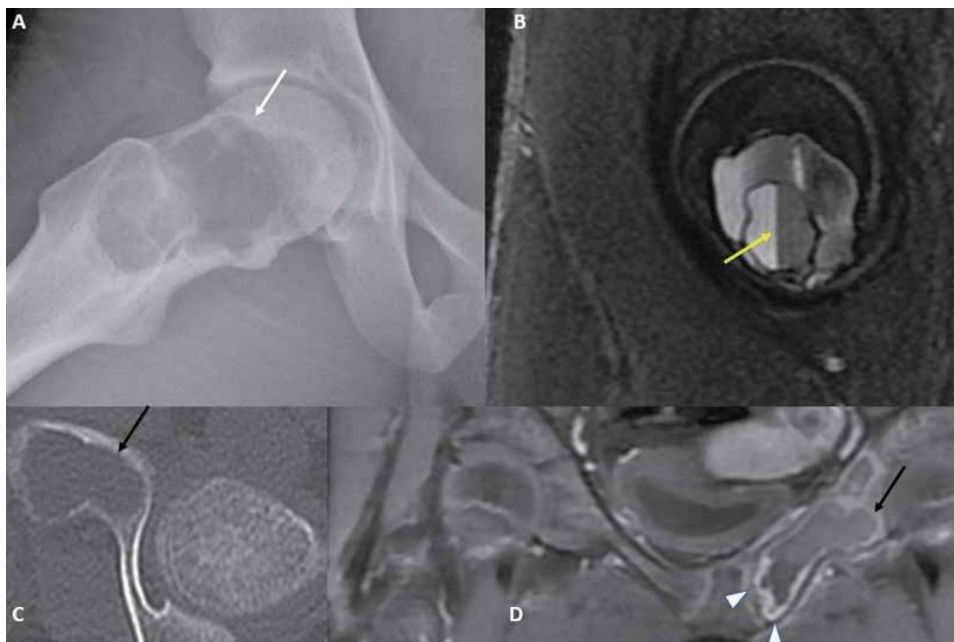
Aneurysmal Bone Cyst: Lateral radiograph of the pelvis (A) shows an expansile, circumscribed, lytic, proximal femoral metaphyseal lesion (white arrow) with scalloped margins. On axial fat-saturated T2-weighted imaging (B), the lesion shows multiple fluid-fluid levels within (yellow arrow), suggesting an aneurysmal bone cyst. C and D are images of an aneurysmal bone cyst in the left pubic bone in a different patient. The aneurysmal bone cyst appears as a well-circumscribed lytic lesion on CT (C). Coronal T1-weighted fat-saturated post-contrast image (D) depicts heterogeneous and peripheral enhancement of the aneurysmal bone cyst.
